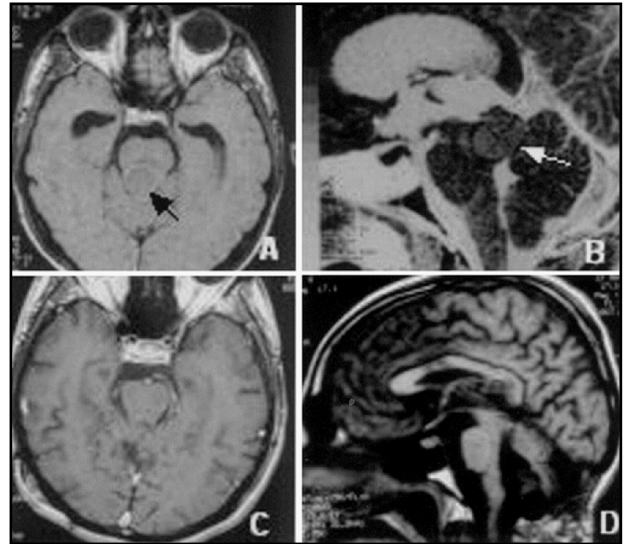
A, B - Preoperative MRI with gadolinium showing no enhancement (arrows). C, D - Postoperative MRI 7 1/2 years after surgery demonstrating total tumor removal.
